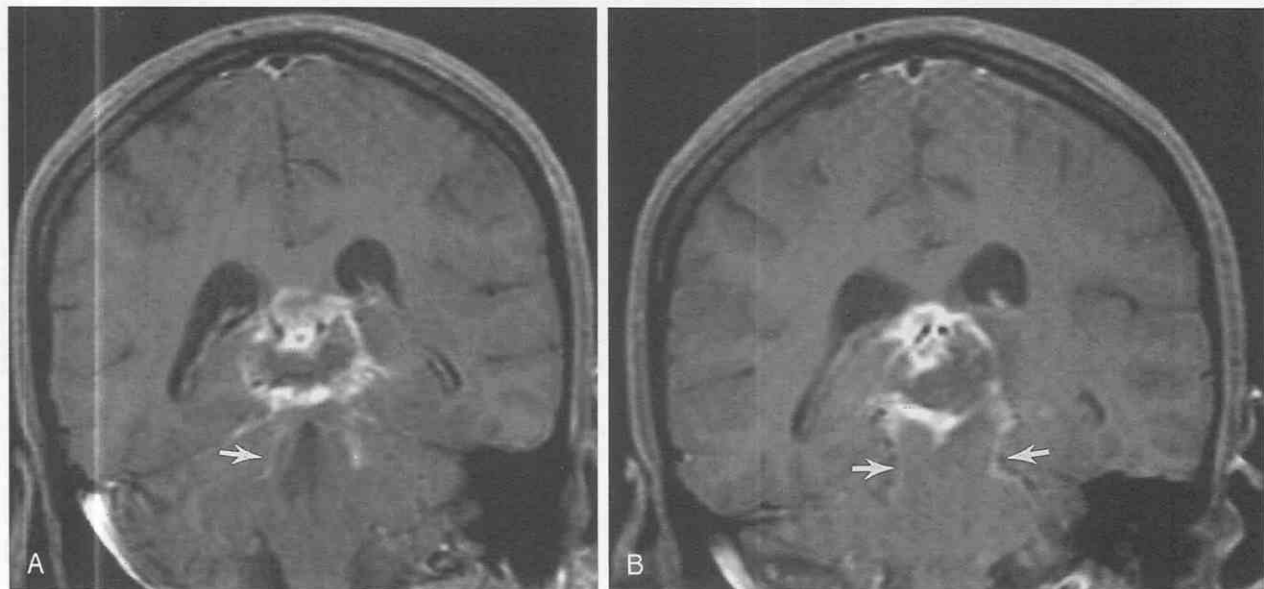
Subarachnoid spread of pineoblastoma. A and B, Coronal enhanced T1-weighted images show the pineal region mass with pia/subarachnoid space enhancement (arrows) in this patient with cerebrospinal fluid dissemination of pineoblastoma.
